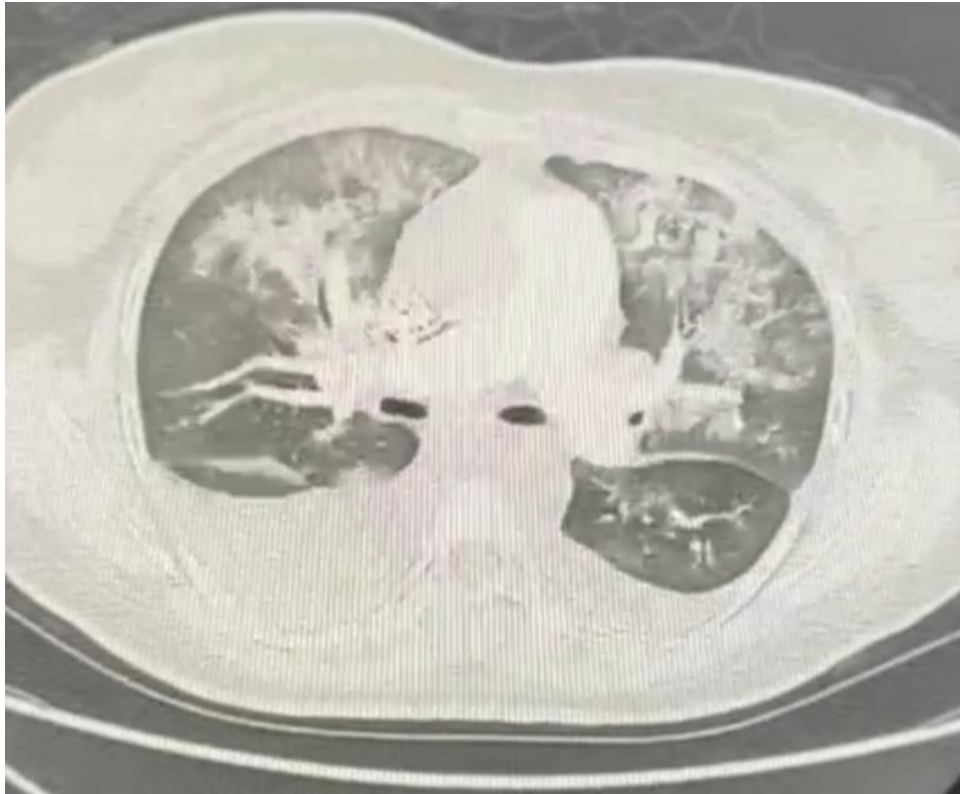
Chest CT scan showing pulmonary parenchymal abnormalities consisting of central and peripheral ground-glass opacities, creating a "crazy paving" appearance with bilateral pleural effusions of fluid density
